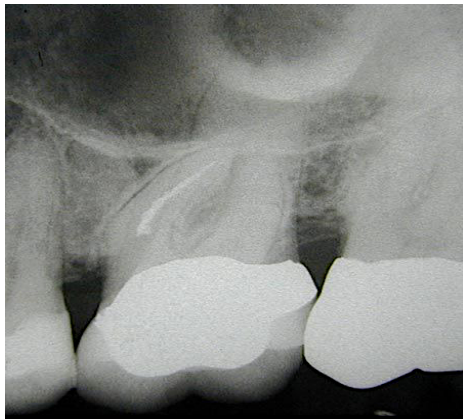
Radiograph showing a crowned molar tooth with a separated NiTi instrument in a very curved root where inadequate straight-line access could have been a factor. From "A practical guide to endodontic access cavity preparation in molar teeth," by S. Patel and J. Rhodes, 2007, *British Dental Journal*, 203(3), p.137.
